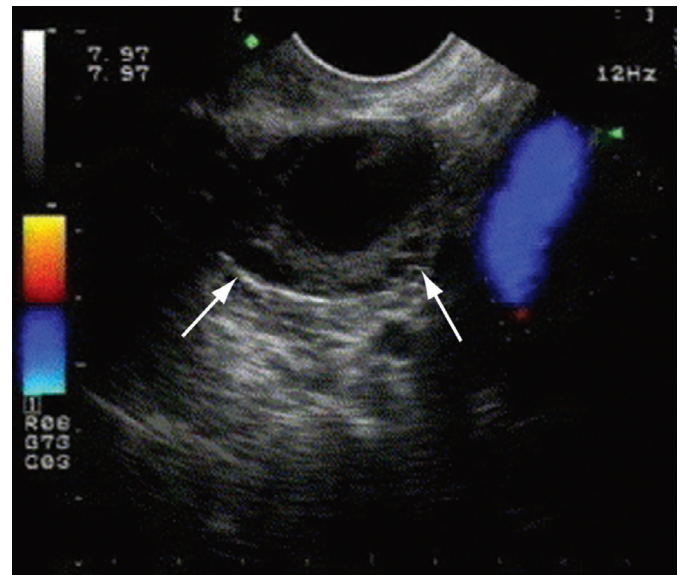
Endovaginal ultrasound image of a normal ovary with a dominant follicle (arrows). (From Lambert MJ, Villa M: Gynecologic ultrasound in emergency medicine. *Emerg Med Clin North Am* 22: 683–696, 2004.)
